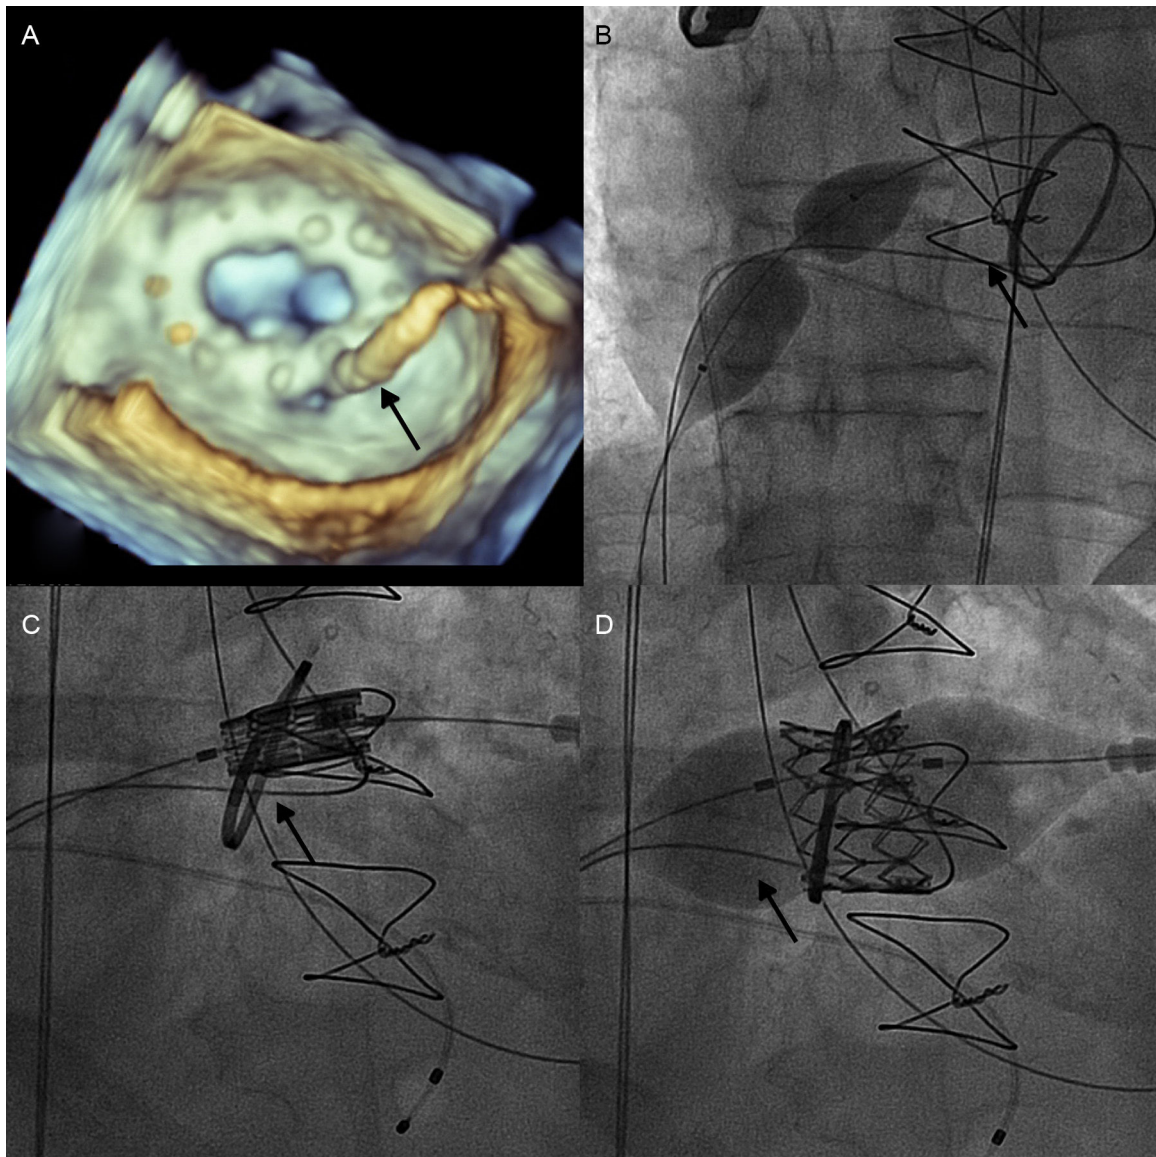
A: Three-dimensional transesophageal echocardiography of the wire (arrow) crossing the paravalvular leak. B: Balloon septostomy. C: Advance of the 29 Edwards SAPIEN XT valve into the mitral ring. D: Valve implantation, with 80% of the valve into the left ventricle.
